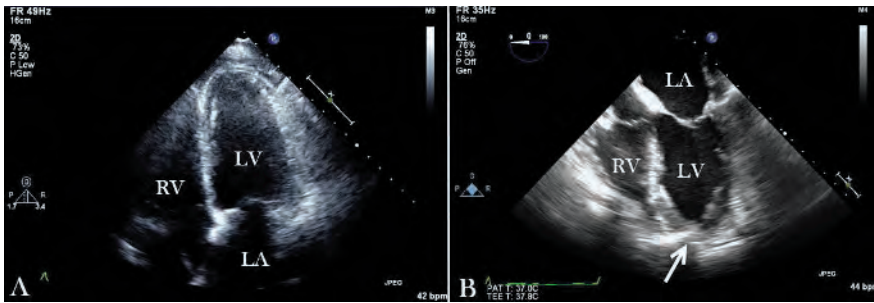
Transapical echocardiographic imaging. (A) Transthoracic image of LV apex obtained immediately prior to skin incision to pinpoint rib space for transapical approach. (B) Intraoperative transesophageal echocardiogram demonstrating indentation from the surgeon's finger on the LV apex to identify optimal location for LV puncture. Arrow, indentation on LV apex. LA, left atrium; LV, left ventricle; RV, right ventricle.
